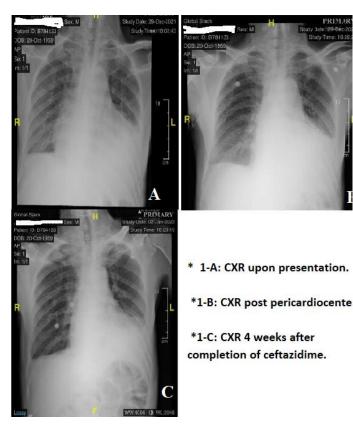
Chest X-ray of the patient. A: upon presentation, B-after pericardiocentesis, and C: one months after completion of antibiotics
